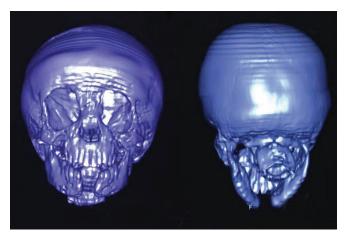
Preoperative CT image
